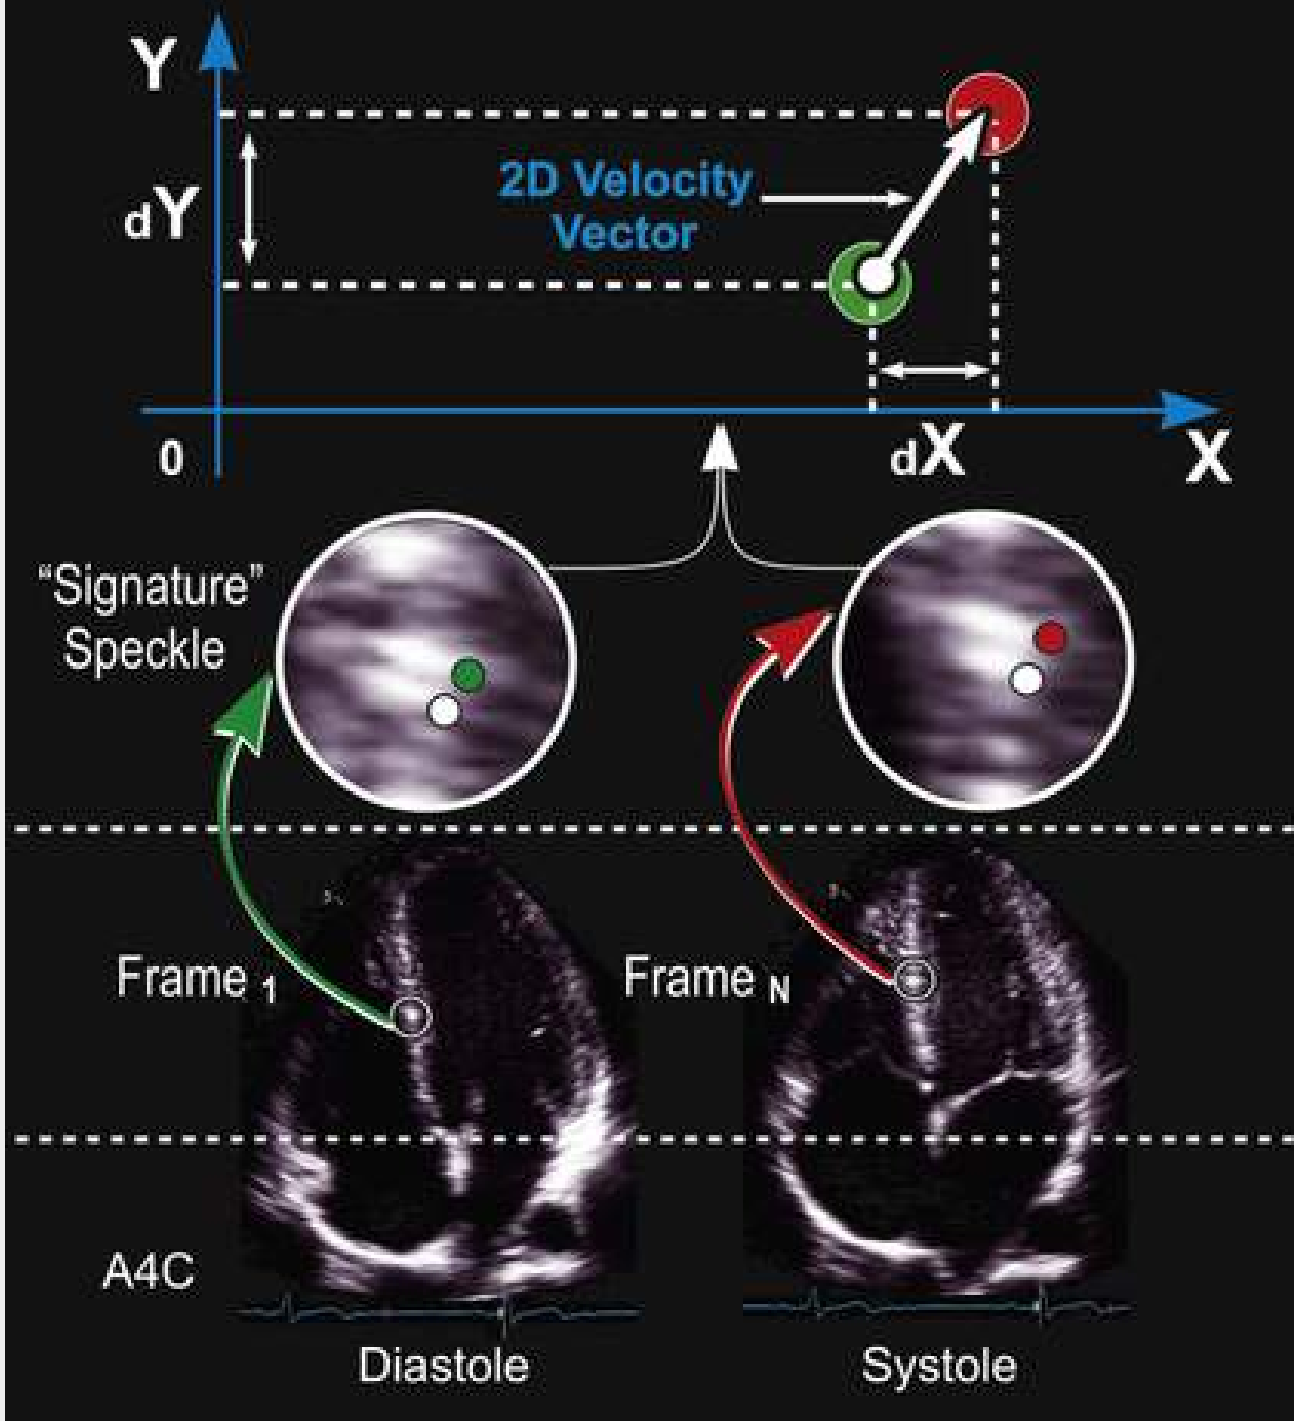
Two-dimensional (2D) speckle tracking methodology. Speckles are inhomogeneous interference patterns that result from the interaction of ultrasound with the myocardium. Each area of myocardium, with its unique signature speckle, can be tracked during the myocardial deformation cycle. Unlike Doppler-based deformation imaging measures, speckle tracking–derived deformation measures are angle independent. A4C, Apical four-chamber view.
